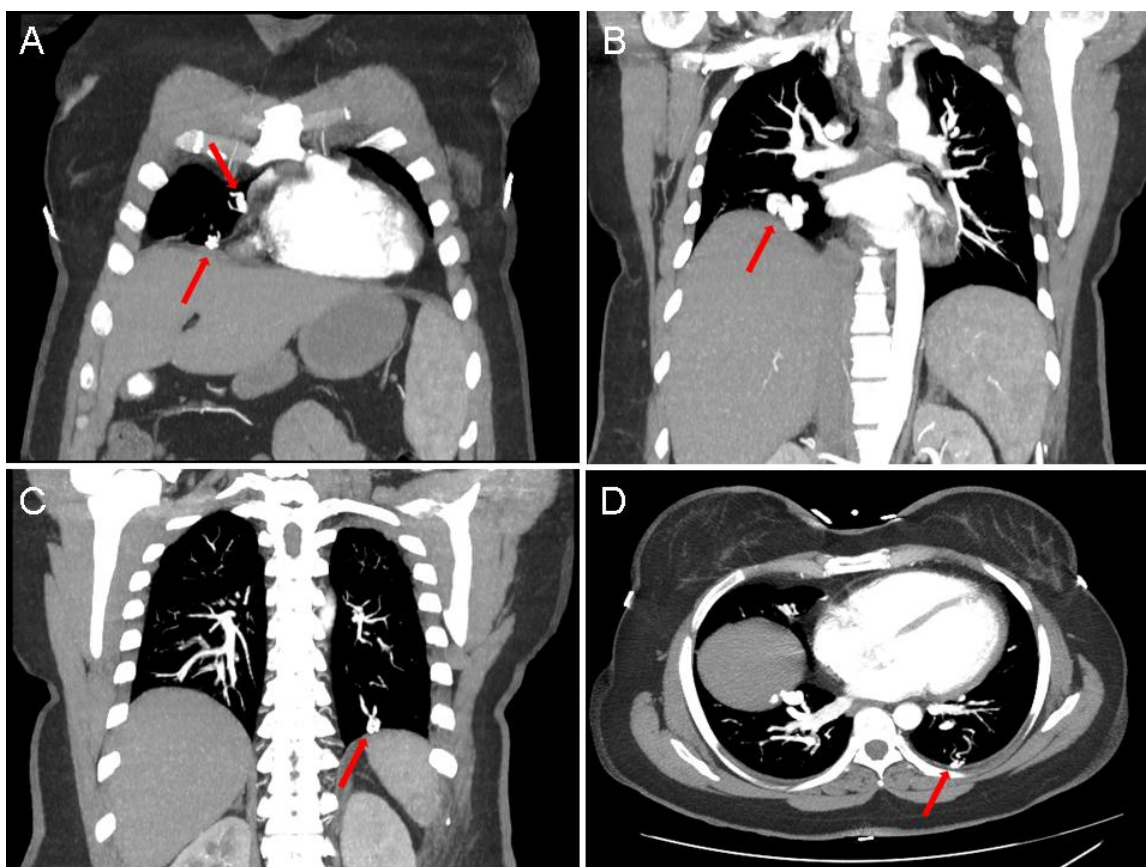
Thoracic CT scan showing arteriovenous malformations (AVM's, arrows).
